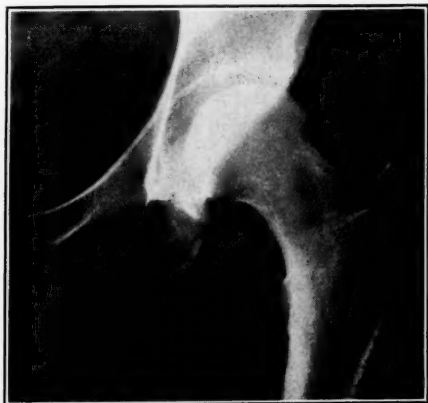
X-ray of left ischium, showing metastasis.
